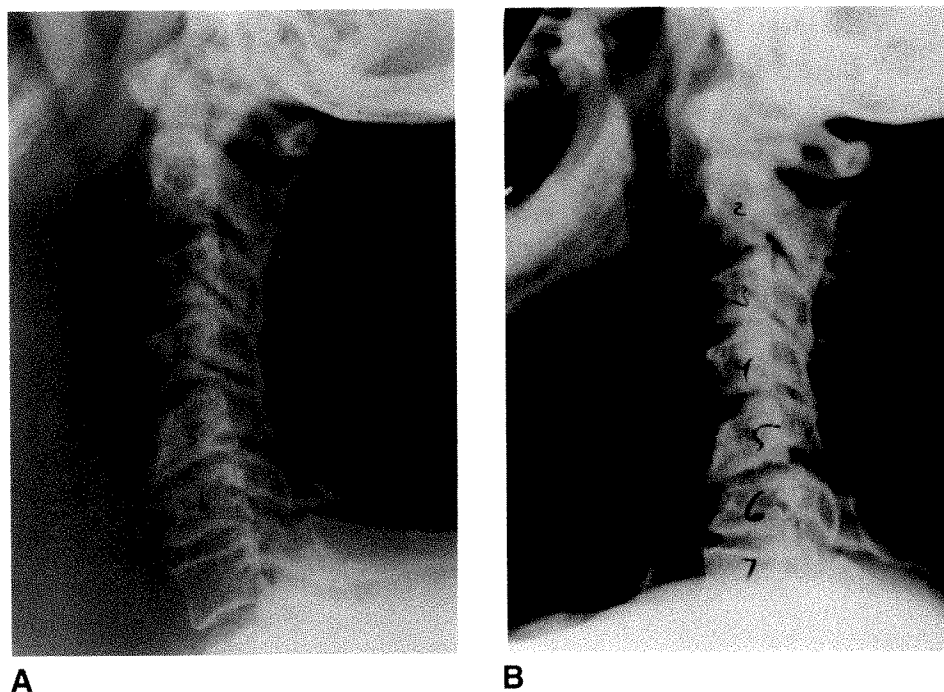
Lateral C-spine roentgenograms of a 63-yr-old man after a motor vehicle accident. The initial roentgenogram (A) shows only degenerative joint disease. A subsequent roentgenogram (B) taken with neck flexion 2 days later shows anterior subluxation at C5-6. The posterior alignment of the vertebral bodies and the spinolaminar line are disrupted at C-6.
